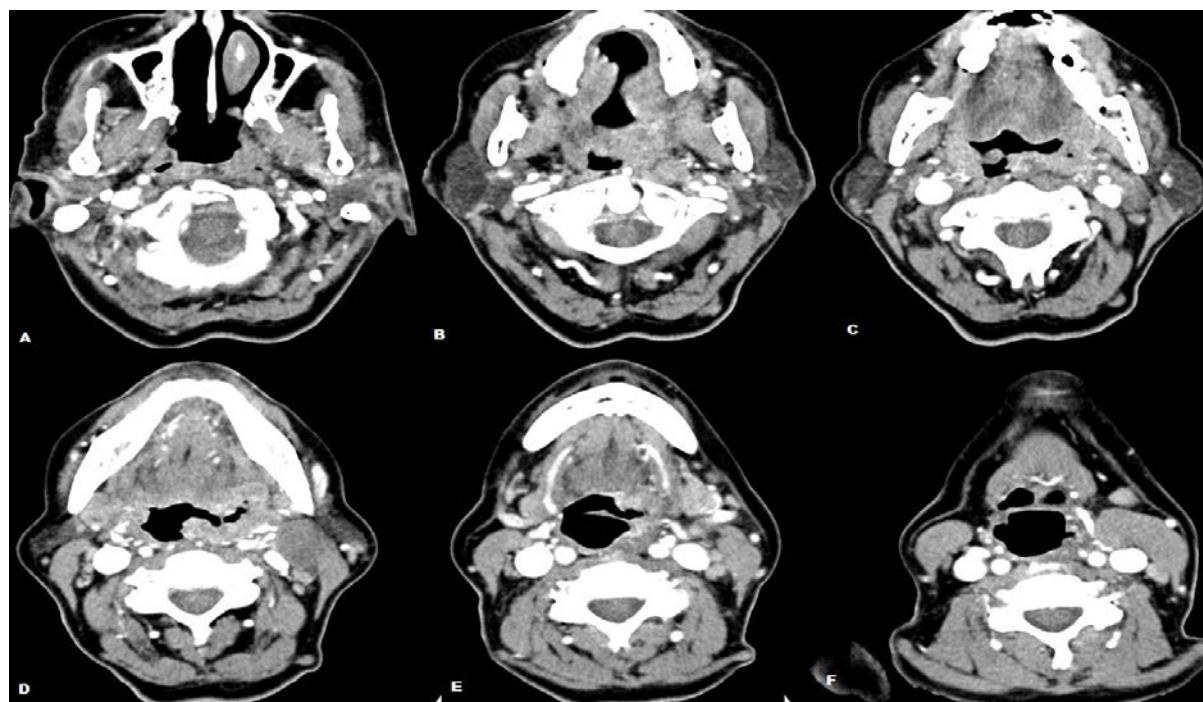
Neck CT-arterial phase: extensive tumor mass in the left latero-posterior wall of pharynx (C) occupying the fossa of Rosenmüller (A), including the left palatine tonsil (B), extended to the left parapharyngeal space (D), infiltrates the left margin of the epiglottis (E), and partially occupies the left epiglottic vallecula (F)
